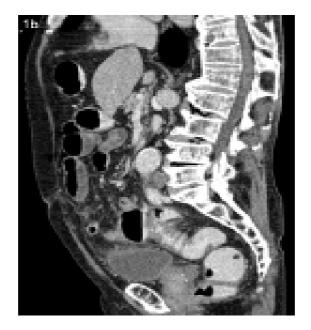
Computed tomography in sagital view showing diffuse thickening of rectosigmoid colon with fat streakiness
